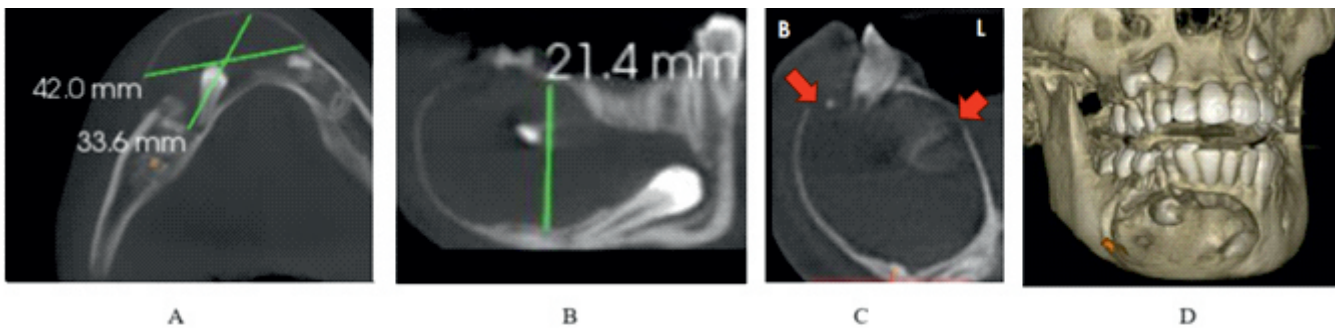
(A) CBCT axial section showing hypodense lesion of size 42mm x 33.6mm extending from 33 to 46 region. (B)CBCT coronal section showing hypodense lesion of 21.4 mm size superoinferiorly extending from alveolar crest upto lower border of the mandible.
